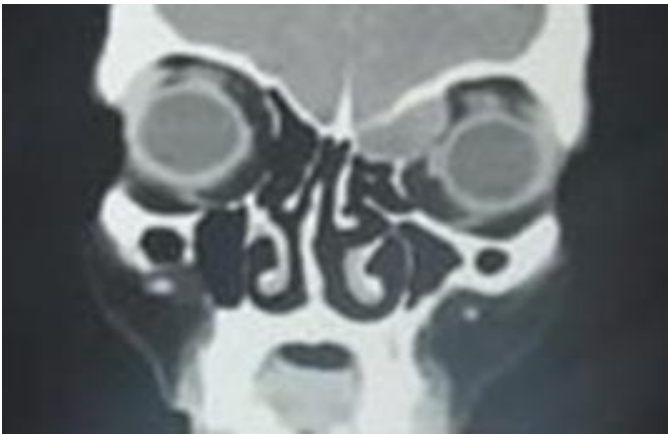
Coronal computed tomography image of anterior ethmoidal mucocele encroaching supra orbital ethmoid cell.
